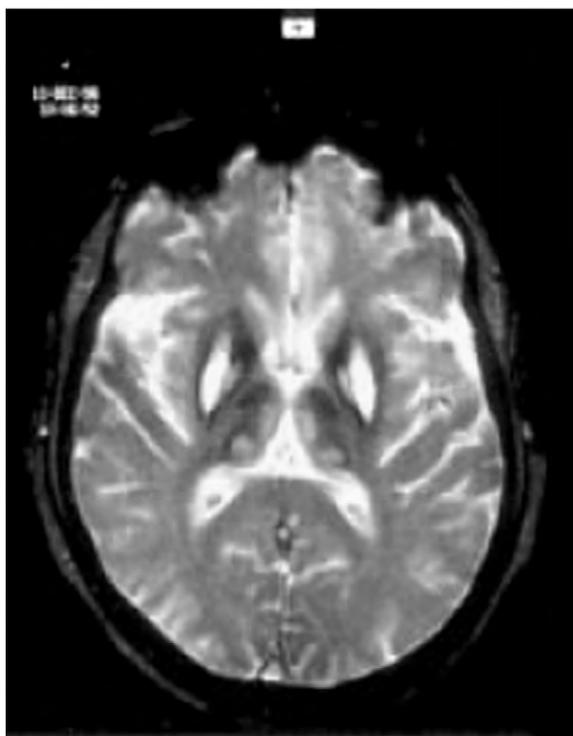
A case of neuroferritinopathy. T2-weighted MRI of the brain shows mixed hyper- and hypointensities affecting the putamen, globus pallidus and thalamus symmetrically.
